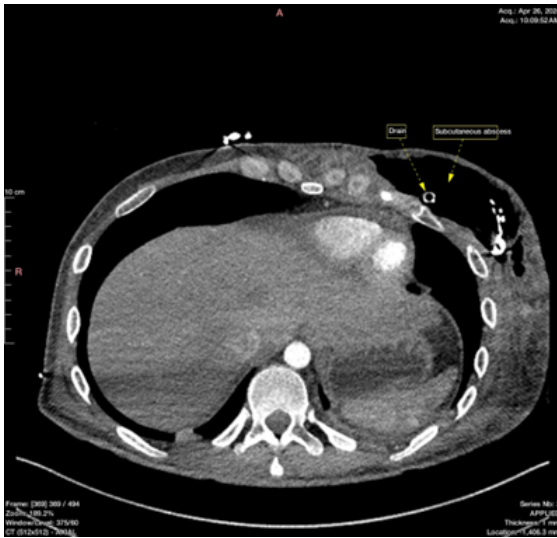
CT Scan Showing the Subcutaneous Collection. The Drain is also Viable in the Collection.
